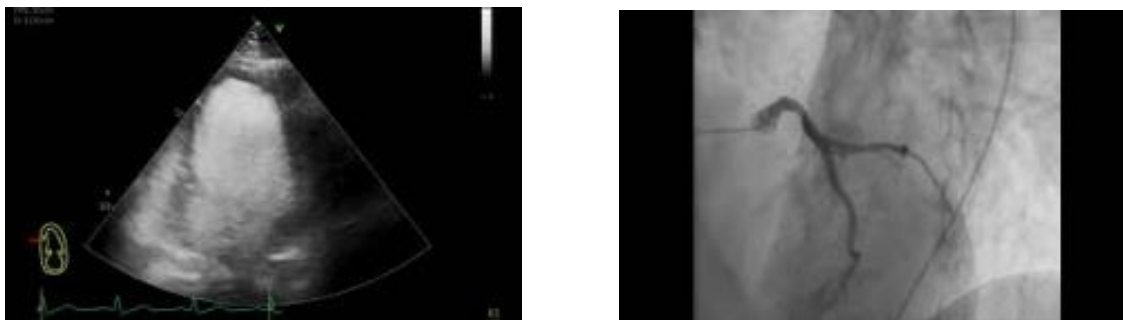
Left heart catheterization & Transthoracic echocardiogram
